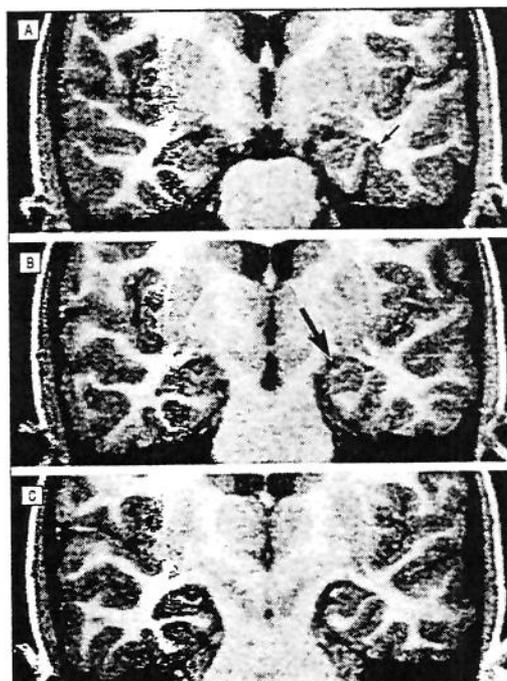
Mesial temporal abnormalities extending to the parahippocampal and fusiform gyri, as well as the collateral sulcus (small arrow) on the left (A) in a 7-year-old, asymptomatic girl with left hippocampal atrophy (arrow) (B) determined by magnetic resonance imaging volumetric measurements (C) (patient 9 in the Table).
